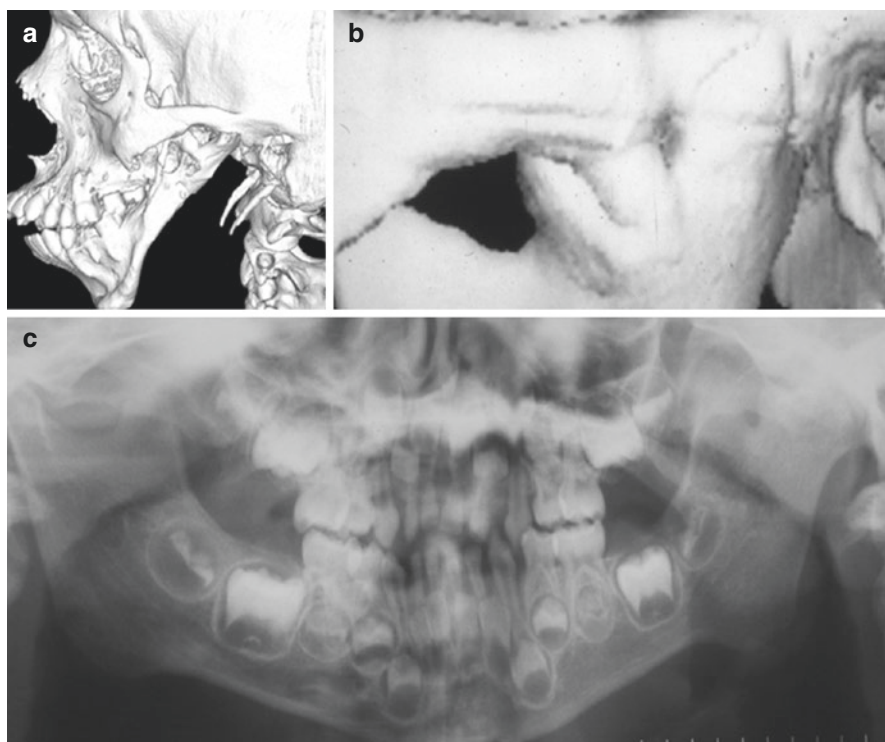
(a) Coronoid hypertrophy, not true TMJ ankylosis, (b) CT with 3D reconstruction showing true (osseous) ankylosis, (c) panorex showing left TMJ osseous ankylosis
